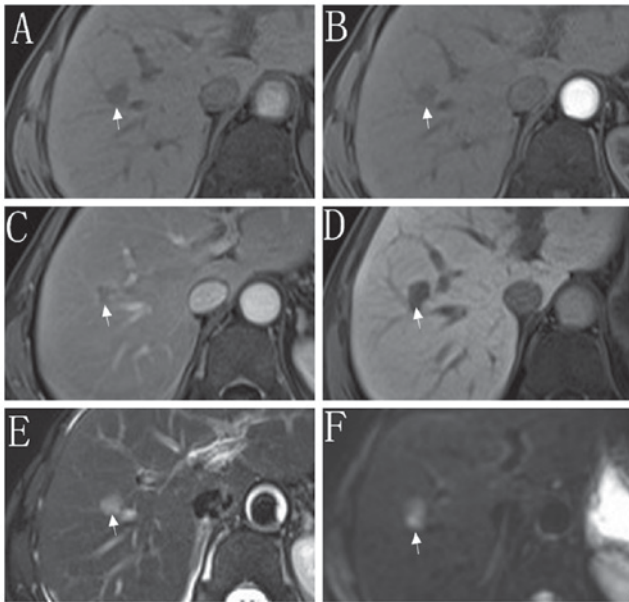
Gadoxetate acid-enhanced magnetic resonance images in a 50 year-old man with hepatitis B-induced liver cirrhosis. (A) Pre-contrast magnetic resonance images indicated a 16-mm nodule (arrow) in the right lobe of the liver. (B) The nodule was indicated to be hypo-intense in the hepatic arterial phase; (C) to have a washout appearance with the absence of a capsule in the portal venous phase; (D) hypo-intense in the hepatobiliary phase. The nodule was categorized according to Liver Imaging Reporting and Data System 4 with ancillary findings of (E) mild-moderate T2 hyper-intensity and (F) restricted diffusion.
